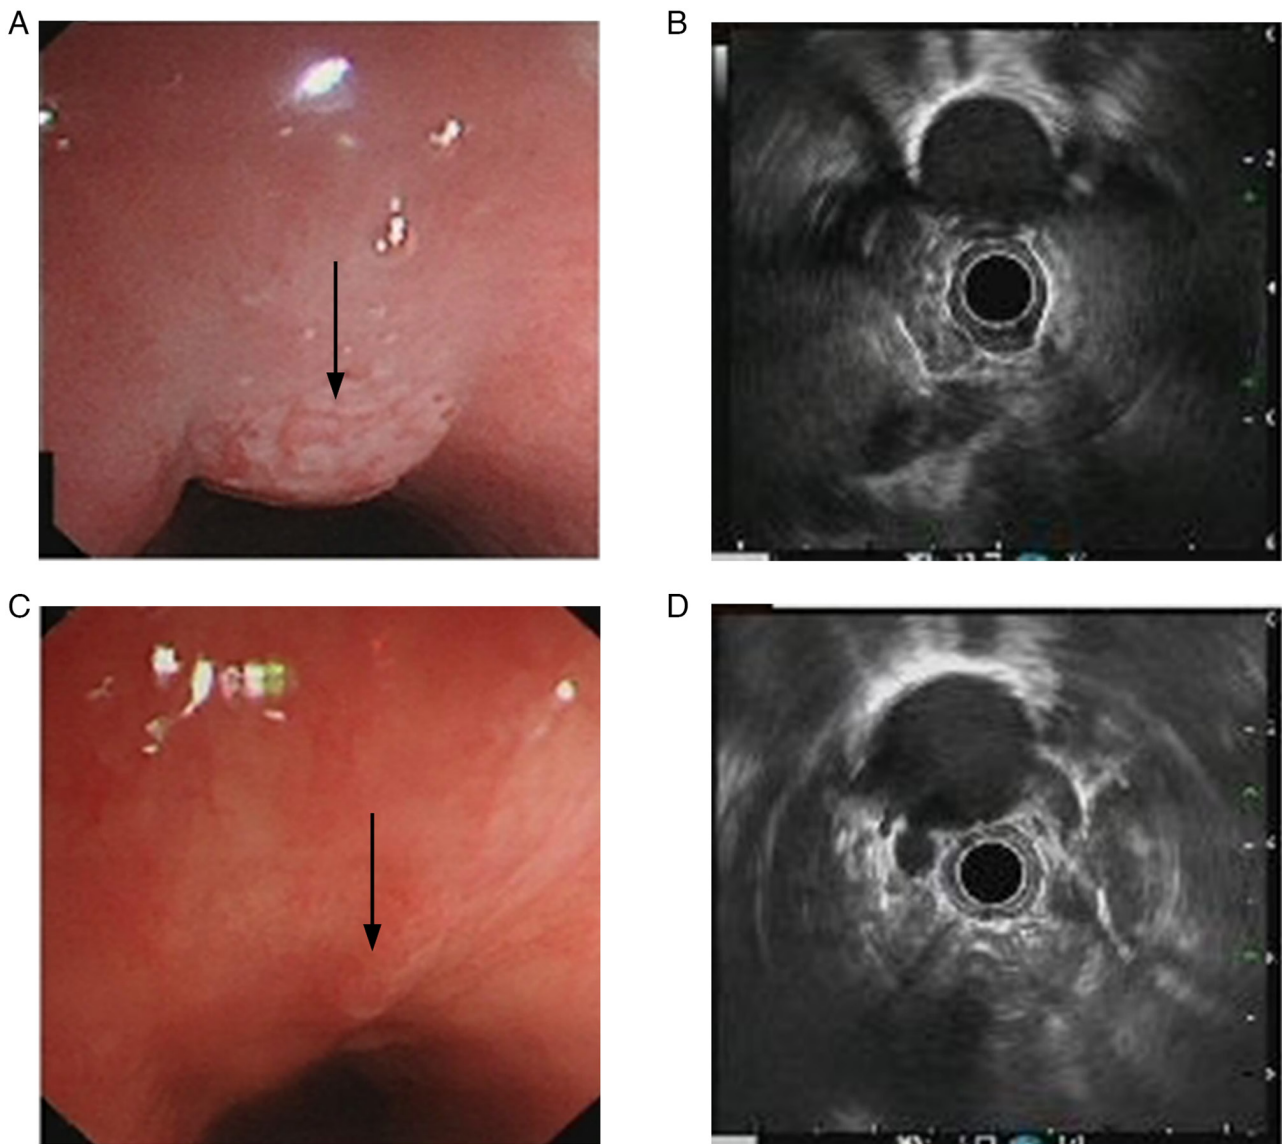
Upper gastrointestinal endoscopy results. (A) Pretreatment endoscopy revealed an elevated lesion with slight erosion on the surface (arrow). (B) Pretreatment ultrasonography suggested invasion into the muscularis propria, and two hypoechoic nodules were detectable in the mediastinum next to the lesioned esophagus. (C) Following three courses of neoadjuvant treatment, endoscopy revealed a reduction in the lesion size (arrow). (D) Post-treatment ultrasonography revealed a reduction in the lesion size.
